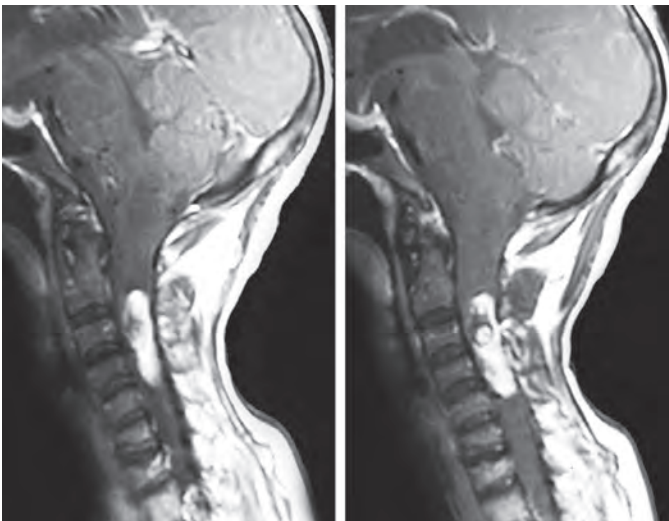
MRI (gadolinium enhanced T1-weighted) cervical spine sagittal section showing intramedullary ependymoma
